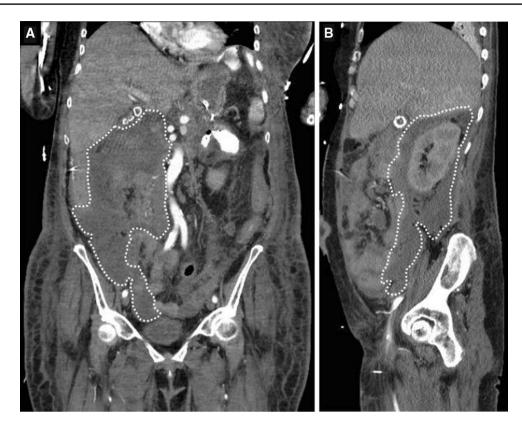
Case #3. a Coronal CT image of right-sided walled-off necrosis (WON; dotted line). b Sagittal CT image of WON
